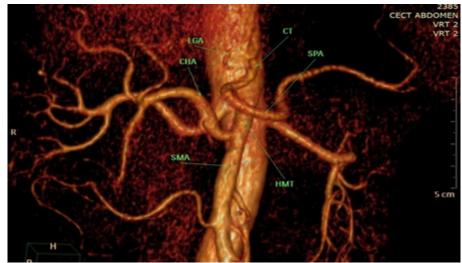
CT Angiogram, volume rendered image showing Hepatomesentric trunkwith Gastrosplenic trunk
